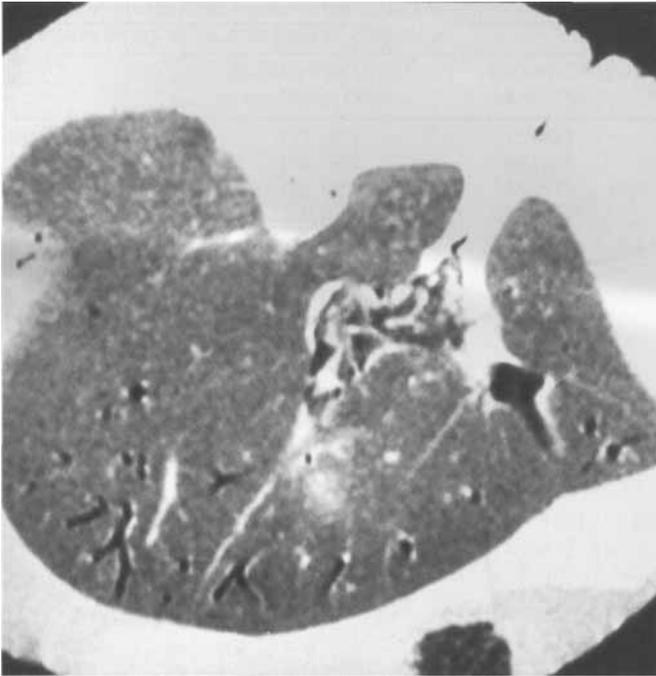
Magnetic resonance image through a donor liver demonstrating air collections deep into the peripheral hepatic veins
